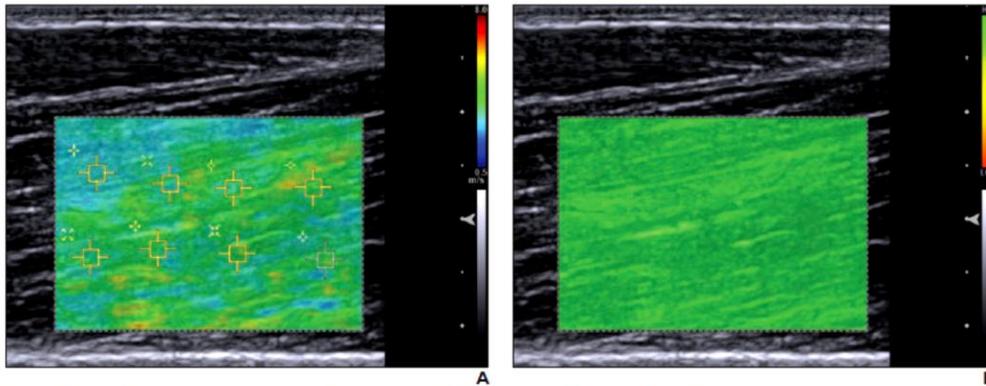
Color-coded shear-wave ultrasound elastography maps of 40-year-old male volunteer (male volunteer 5 in Tables 1 and 2). Maps were obtained using Virtual Touch Tissue Imaging Quantification (VTIQ, Siemens Healthcare) software.
